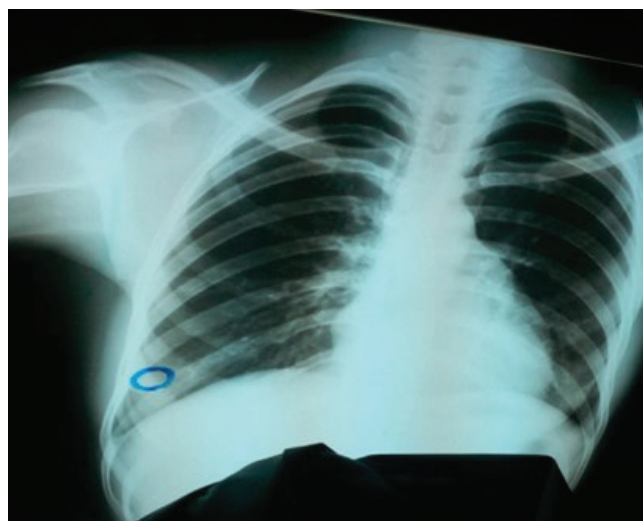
Case 5. X-ray. Coin like lesion in right lung (Credit: Kizza Paul and Paula Nuer)
